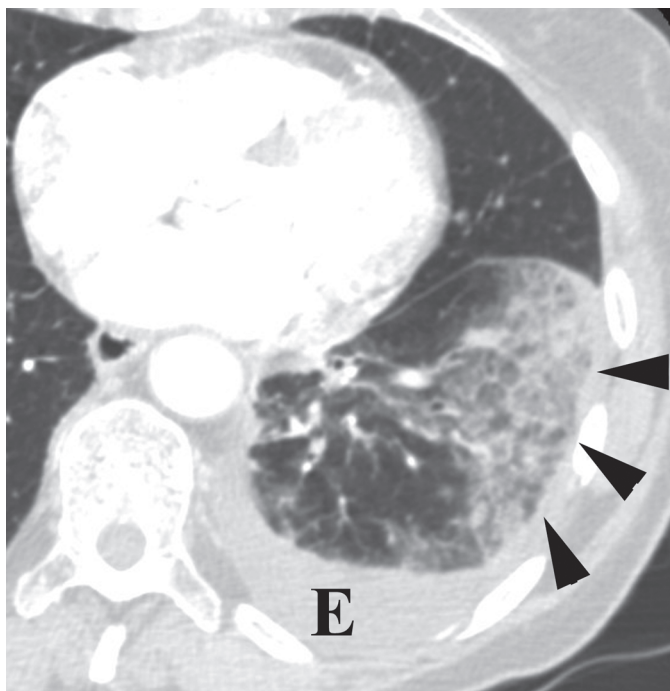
Pulmonary infarct on computed tomography. Axial image reveals wedge-shaped area of mixed ground glass opacity and consolidation (arrowheads) with associated pleural effusion (E).
